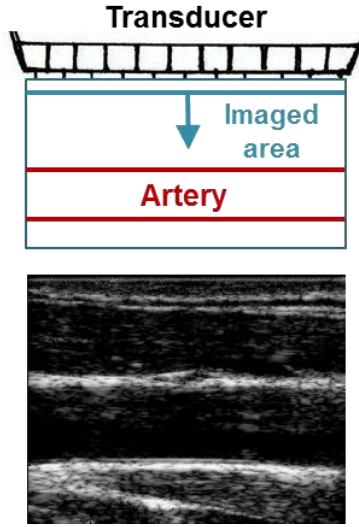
In the plane wave ultrasound architecture, all transducer elements are excited at once, sending a single plane wave into the tissue. The image is reconstructed using delay-and-sum beamforming techniques.
